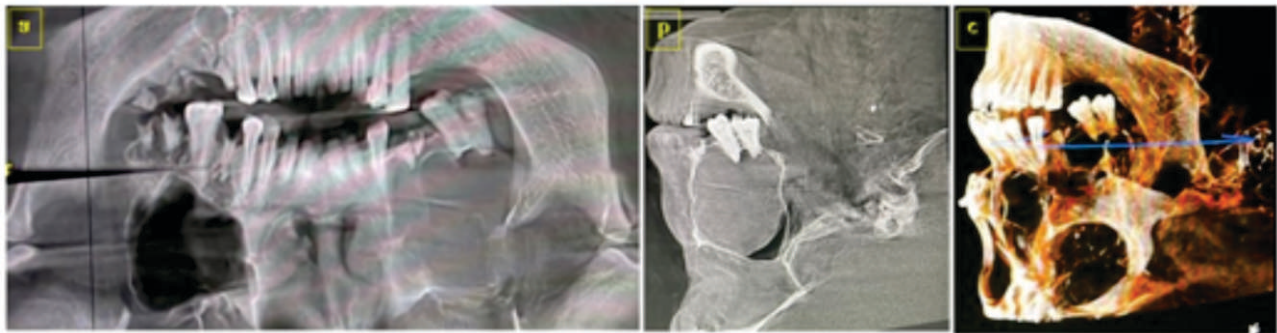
b & c : OPG, CBCT and 3D construction image showing the involvement of lesion from periapical area to the maxillary sinus.
